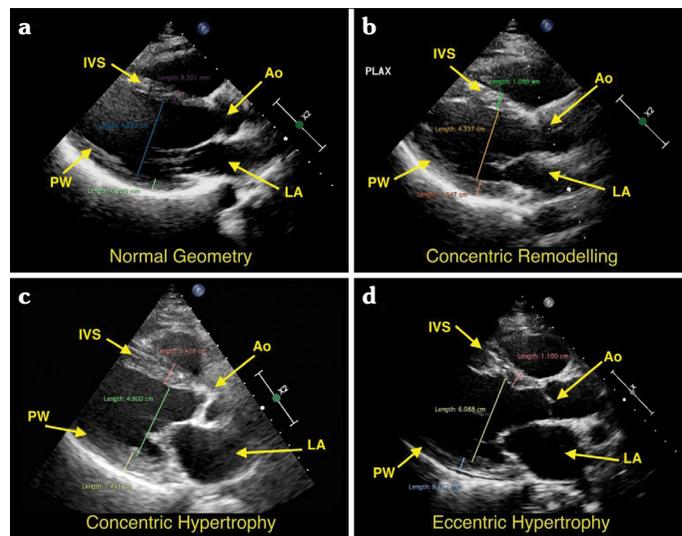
TTE parasternal long axis views demonstrating various left ventricular geometry patterns. (a) 52-year-old male patient with normal LV geometry. LVEDd 47 mm; IVSd 8.3 mm; PWT 7 mm; LV mass: 115 g; LV mass index 61 g/m²; RWT 0.30. (b) 61-year-old male patient with concentric remodeling. LVEDd 44 mm; IVSd 11 mm; PWT 10.5 mm; LV mass 164 g; LV mass index 86 g/m; RWT 0.48. (c) 52-year-old male patient with concentric hypertrophy. LVEDd 49 mm; IVSd 14 mm; PWT 14.5 mm; LV mass: 290 g; LV mass index 147 g/m²; RWT 0.59. (d) 67-year-old female patients with eccentric hypertrophy. LVEDd 61 mm; IVSd 11 mm; PWT 9 mm; LV mass: 254 g; LV mass index 132 g/m²; RWT 0.31
